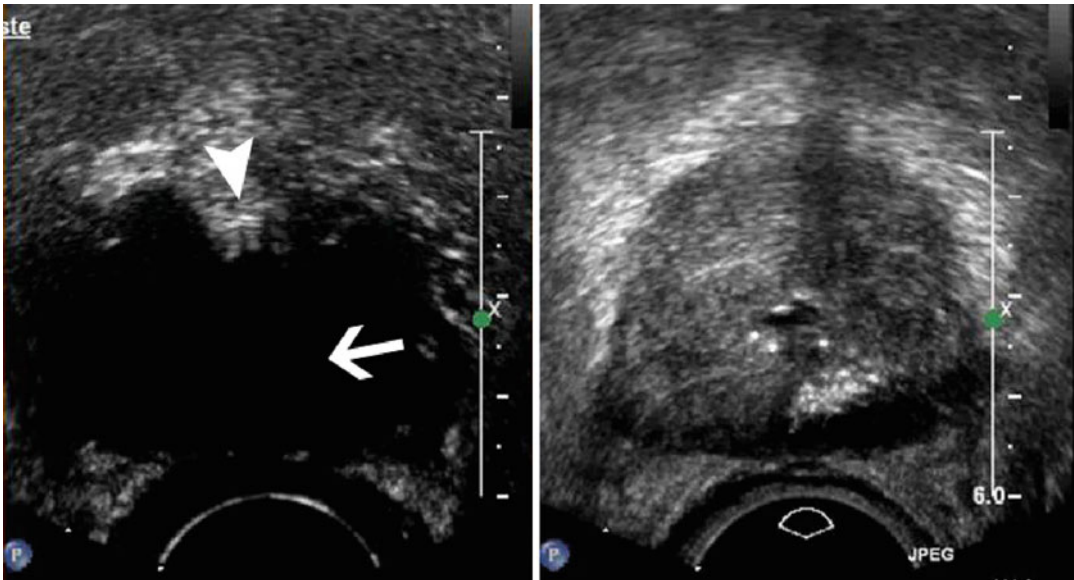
Contrast-enhanced ultrasound (CEUS) axial image (*left part* of the figure), with corresponding low mechanical index gray-scale image (dual mode; *right part* of the figure), obtained after HIFU ablation of a local recurrence of prostate cancer after radiation therapy in a
